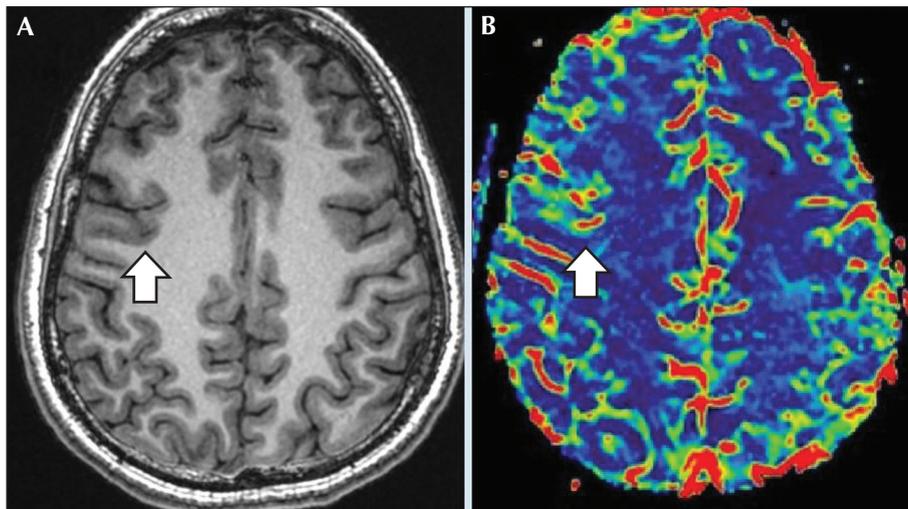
(A) Peri-ictal axial T1-weighted MRI multiplanar (MPR) reconstruction, and (B) axial DSC PWI image. Perfusion-weighted imaging clearly shows focal cortical-subcortical cerebral blood flow increase in the right frontal eye field area, correlating with the ictal epileptic activity.
